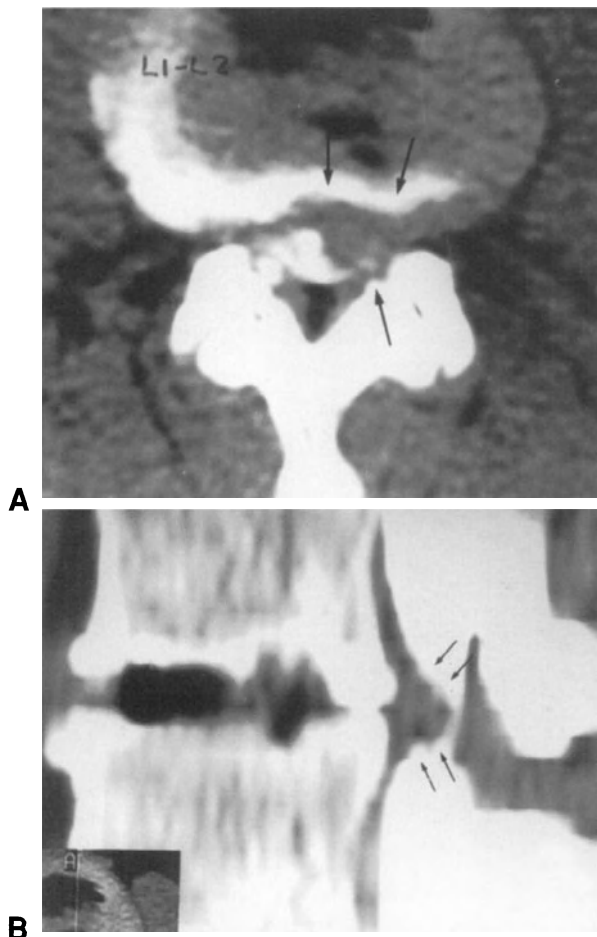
Combined stenosis of the spinal canal associated with disc herniation at L1-L2 level. Axial CT scan (A) and sagittal reconstruction (B) show an extruded herniation on the left (arrows) and a small-sized spinal canal. Laminotomy and discectomy were performed on the left side.
